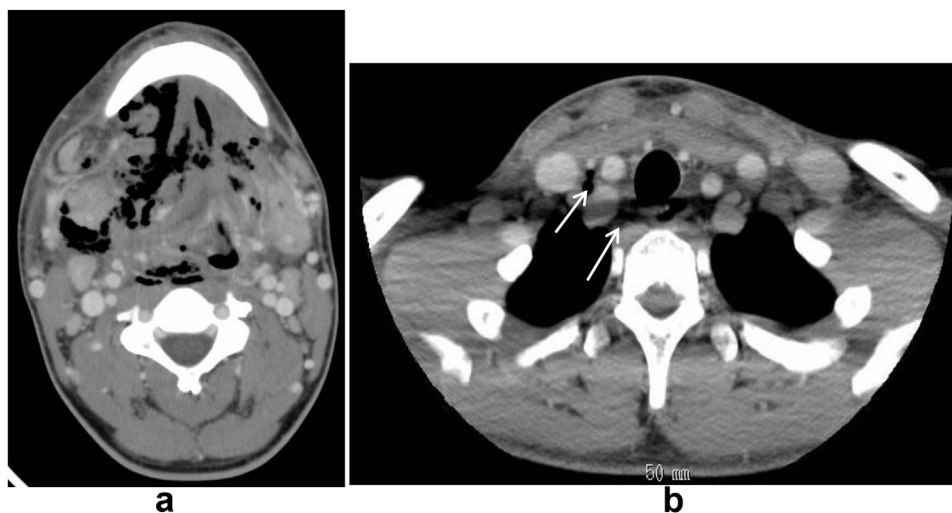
Enhanced CT revealed (a) obvious abscess formation and gas accumulation in the right cervical region and (b) the presence of mediastinal emphysema (arrowheads).
